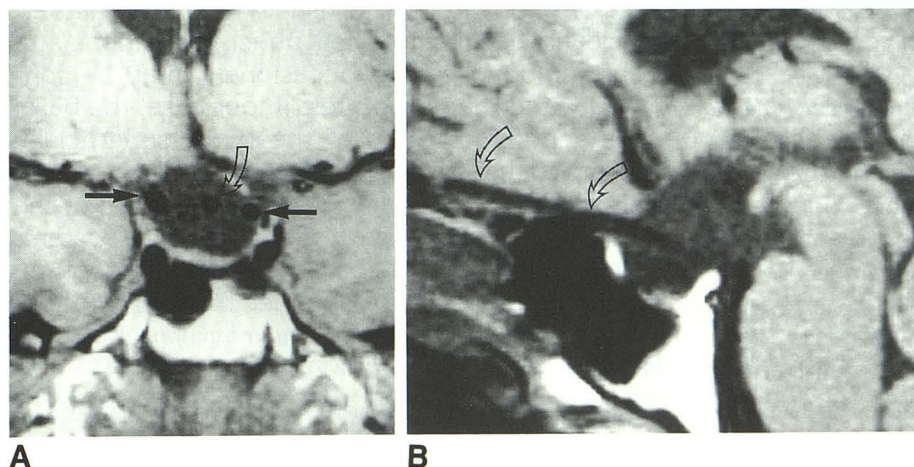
A, Coronal unenhanced T1-weighted spin-echo MR scan (TR/TE/excitations, 483/12/4) shows a small round hypointensity within the center of the suprasellar cistern (*curved arrow*) which is similar to the flow-void within the supraclinoid ICAs (*straight arrows*).
